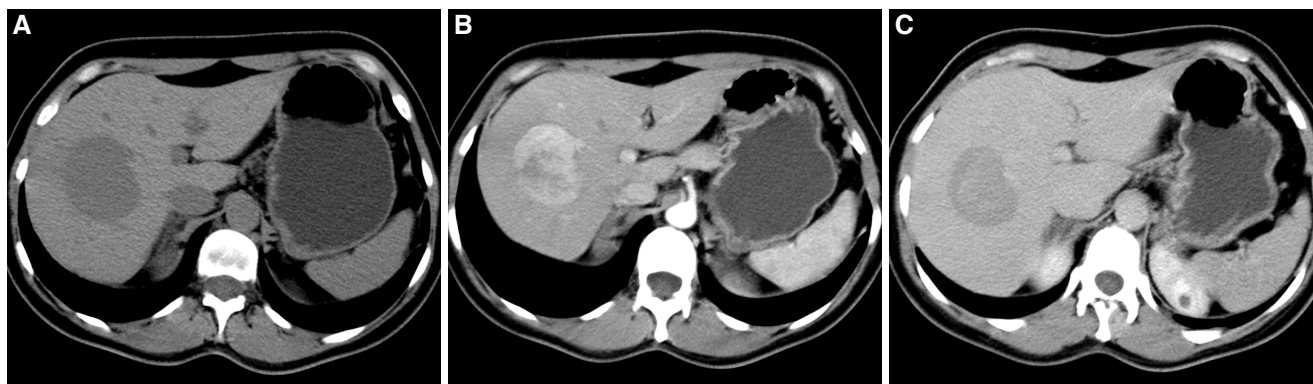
Computed tomography of axial planes obtained in empty (A), arterial phase (B), and portal phase (C). It shows healthy liver with hypodense mass in empty (A) with intense enhancement in the arterial phase (B), and washed-out in portal phase (C). The first radiological and pathological diagnosis was hepatic adenoma. A second biopsy confirmed the diagnosis of hepatocellular carcinoma
